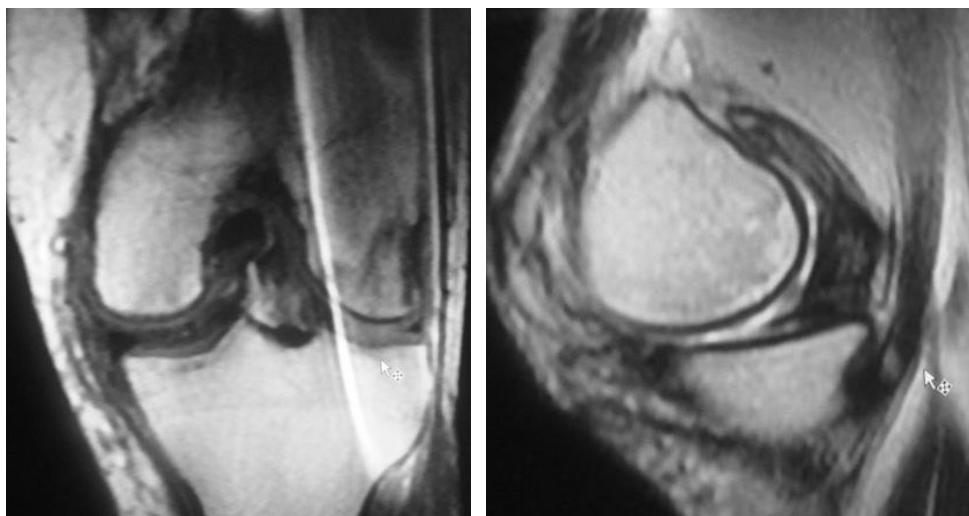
MR images of the knee. MRI is used to accurately assess soft tissue including ligaments and menisci of the knee joints.
